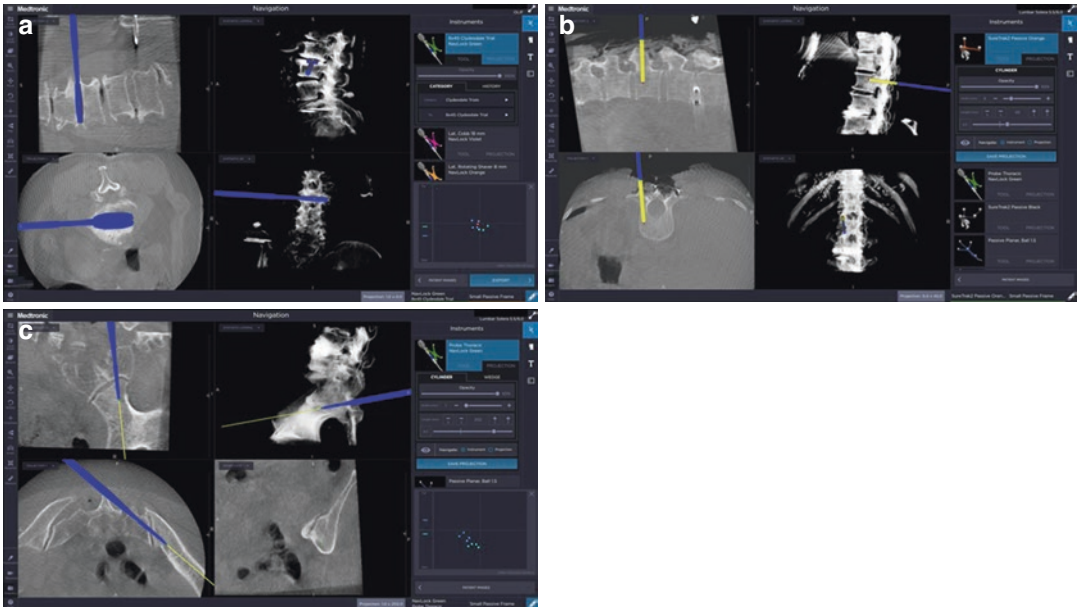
Computed tomography (O-arm)-based navigation surgery for severe adult spinal deformity. O-arm navigation allows the precise placement of minimally invasive
